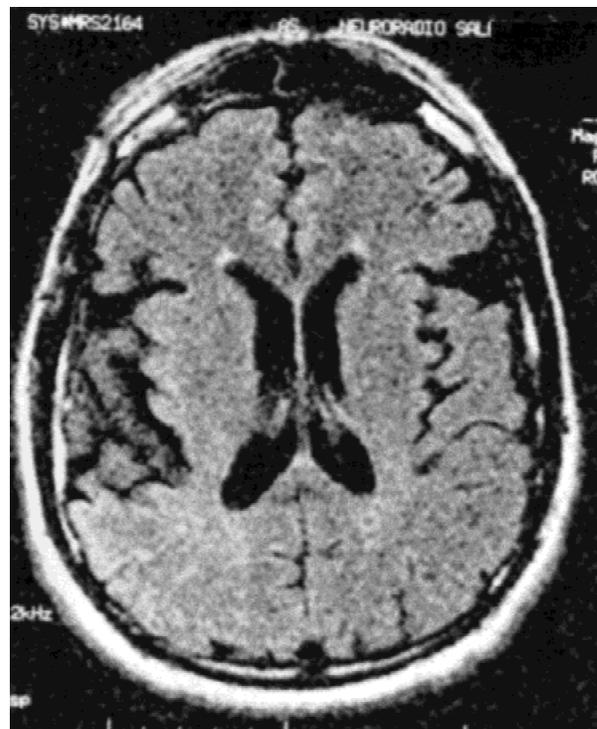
Cranial magnetic resonance imaging (FLAIR) showing diffuse cortical atrophy.
